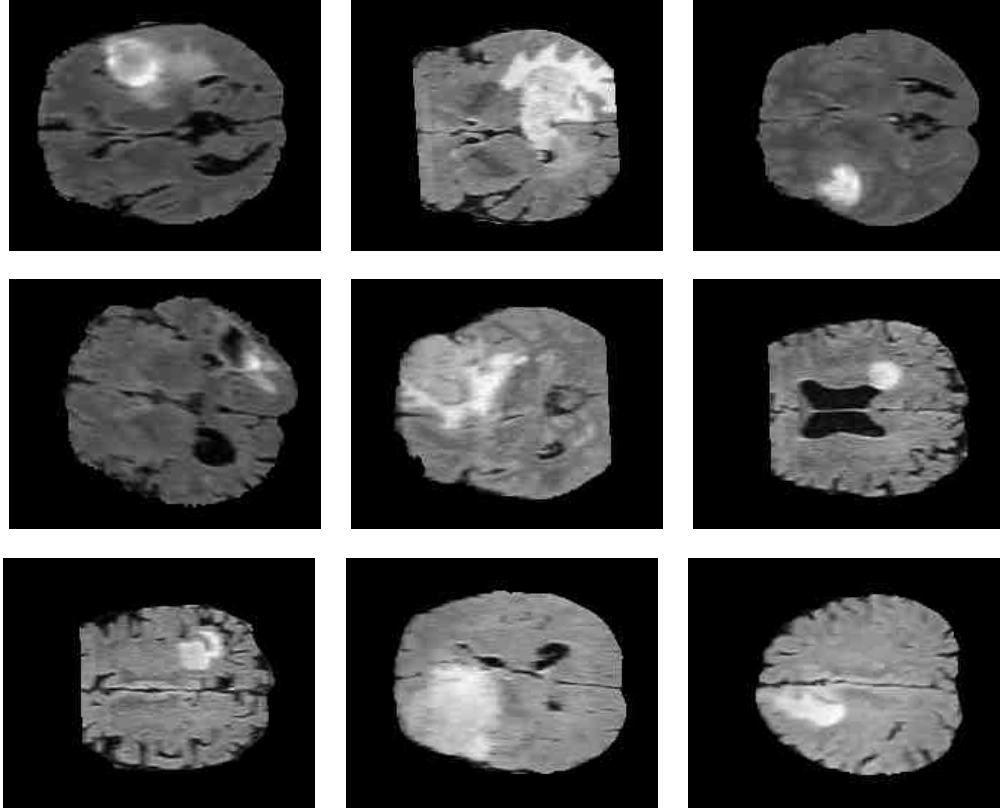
Examples of real FLAIR MR images
